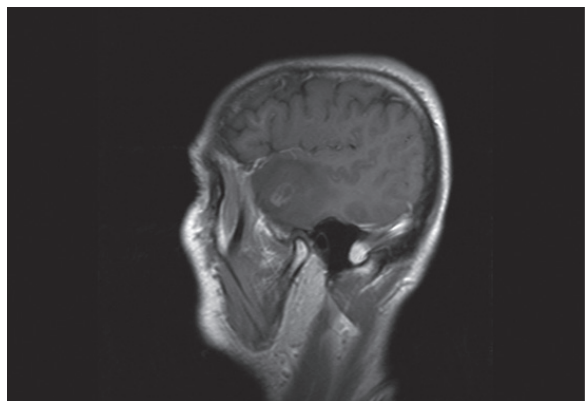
MRI before surgery. Sagittal T1-weighted image. Tumor with an extensive edematous area around it in the right temporal lobe
